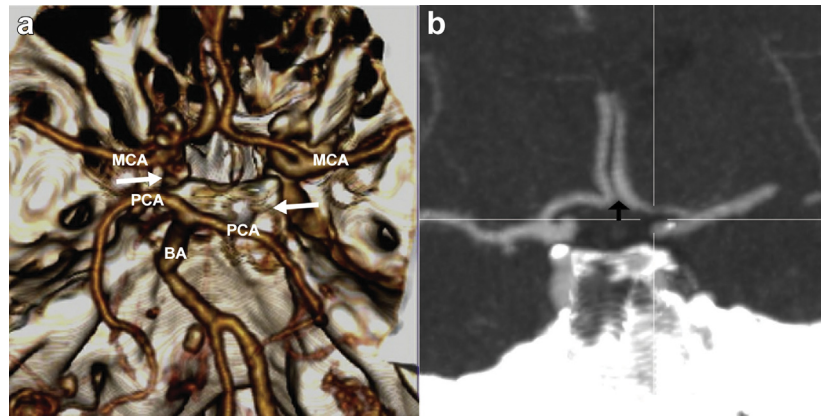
a, A computed tomography angiogram (CTA) of the head revealed an incomplete circle of Willis. The arrows indicate absent posterior communicating branches. BA, Basilar artery; MCA, middle cerebral artery; PCA, posterior cerebral artery. b, The anterior communicating artery (black arrow) was barely detectable.
